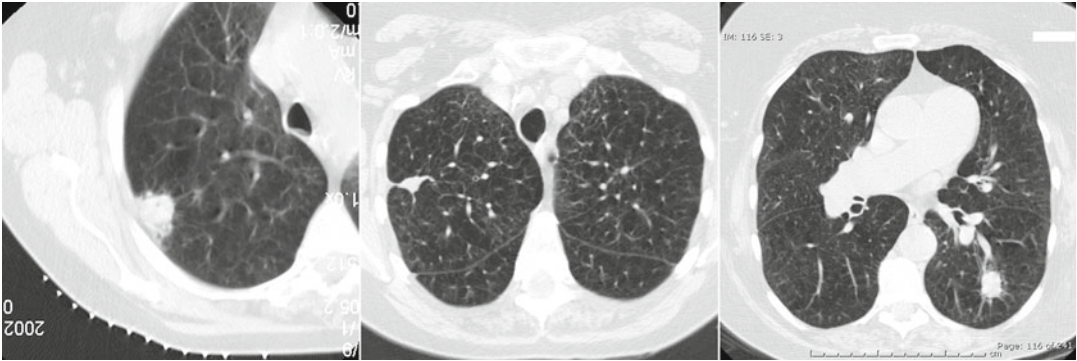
Development of a new primary lung cancer. A mass is present in the periphery of the upper lobe of the right lung (*left*). This was found to be a NSCLC by needle biopsy and was treated with RFA. A surveillance CT
